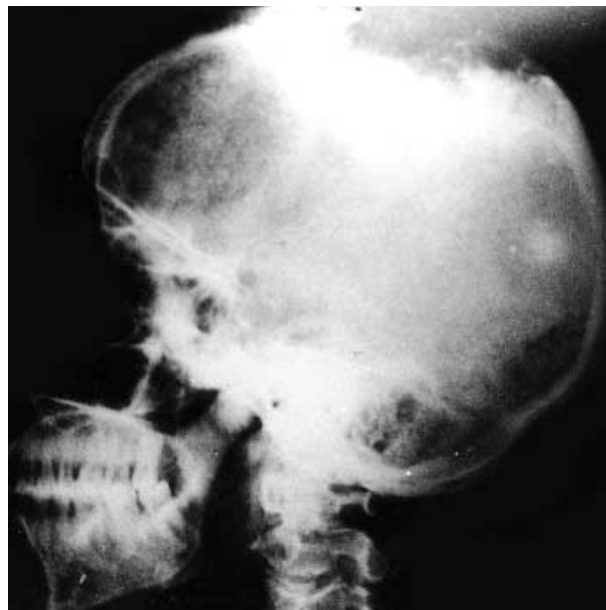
Lateral radiography of the skull showing bony erosion.
